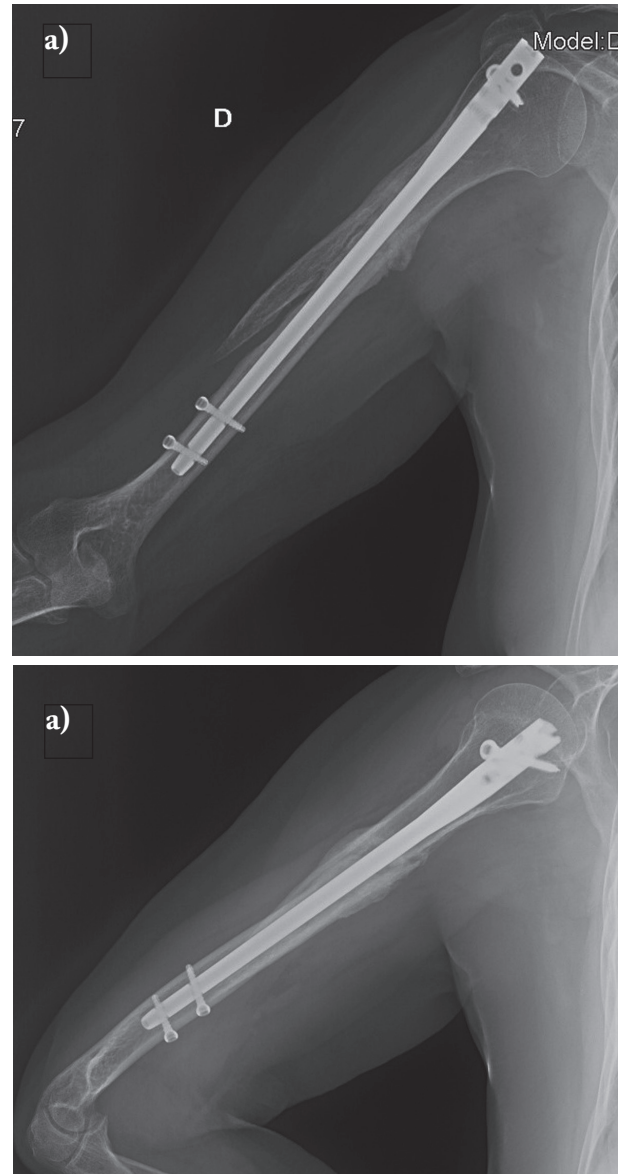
a, b. X-rays 3 months after surgery: despite of the initial gap, bone callus is already visible. The mobilized screw has been removed
